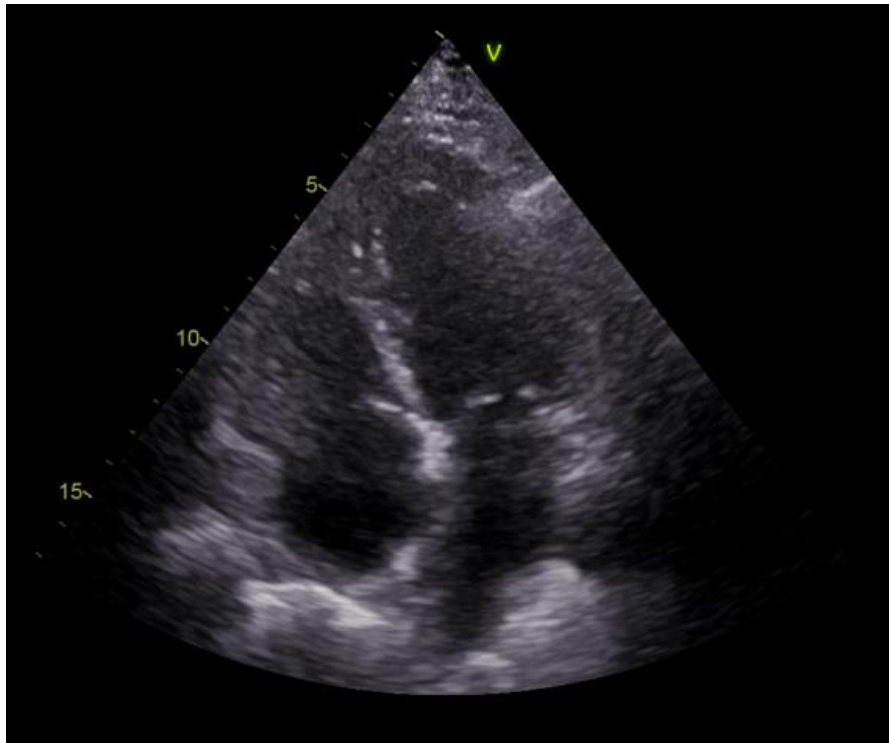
Apical four chamber view of the ventricles and atria.
